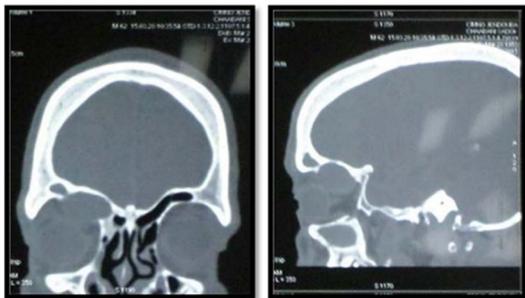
CT scan with coronal and sagittal reconstruction: Mucocele with in the left frontal sinus with erosion of the roof of the orbite and extension into the orbital cavity.
